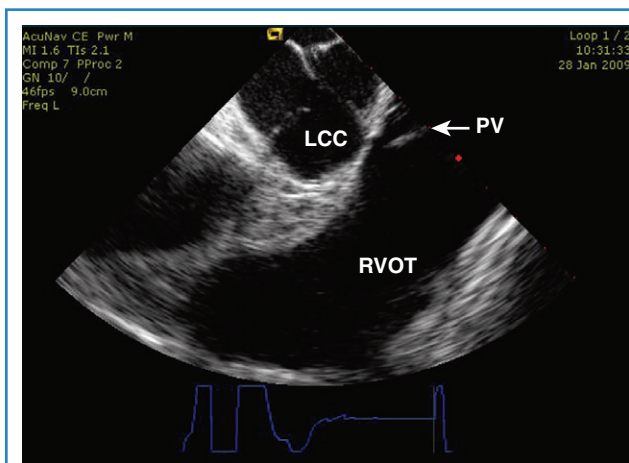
Intracardiac echocardiography (ICE) image of the aortic valve in cross-sectional view. Note the demonstration of the close relationship of the right ventricular outflow tract, pulmonic valve (PV) and the aorta, particularly the left coronary cusp (LCC).
